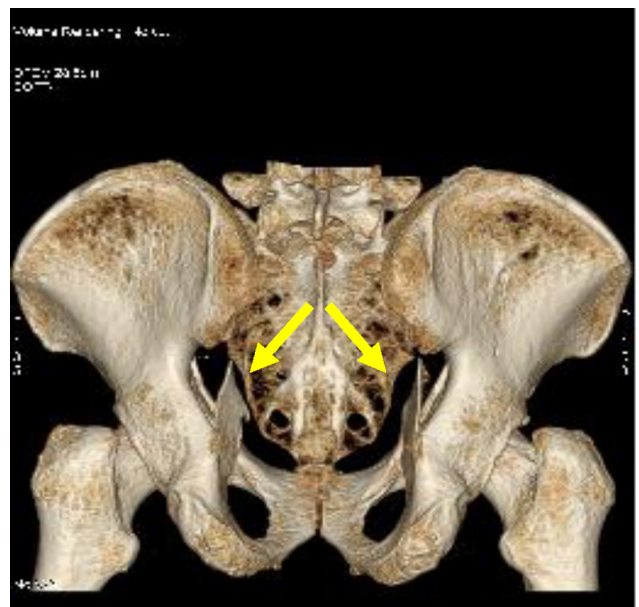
CT-scan showing bilateral quadrilateral plate fracture.
